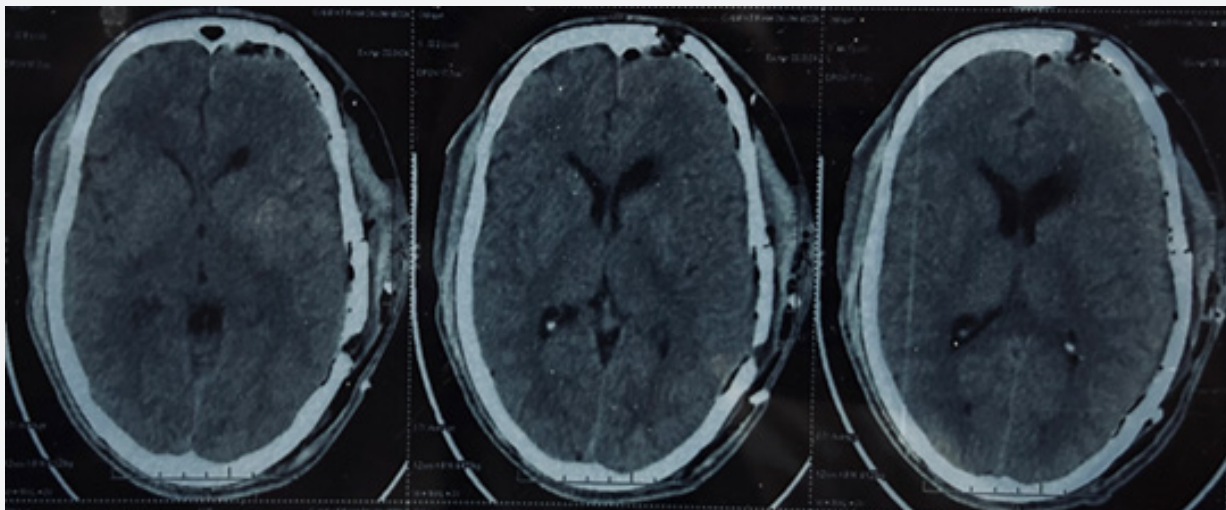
(Post operative CT Brain).
